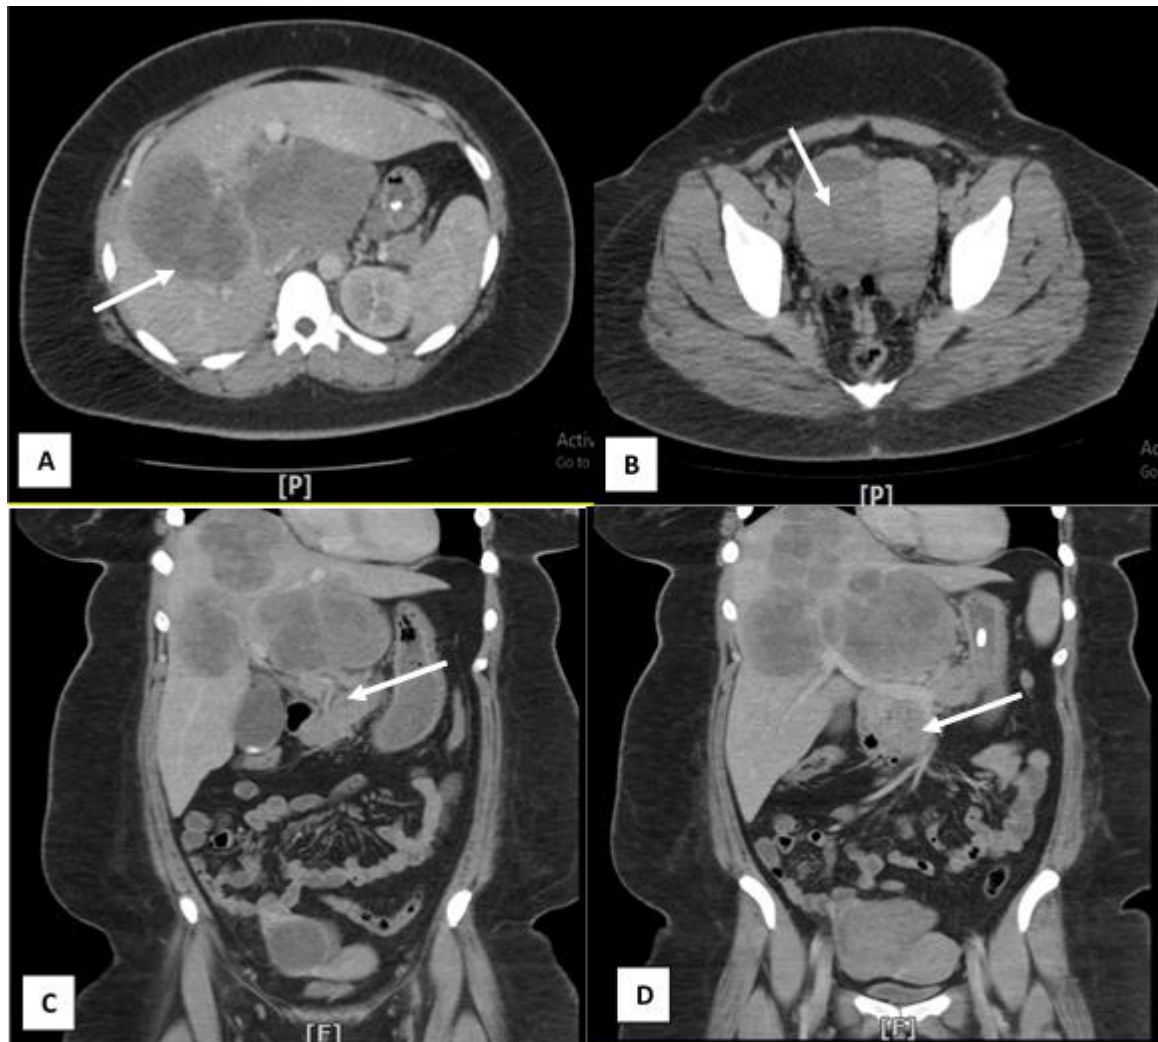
Computed tomography scan transverse section of the abdomen showing multi-lobulated hypodense area in the right lobe of the liver (A) and heterogenous enhancing lesion in the right adnexal suggesting ovarian mass (B)(Arrow). Coronal section of the abdomen showing multiple small paraaortic and paracaval lymph node enlargement (C and D) (Arrows).
